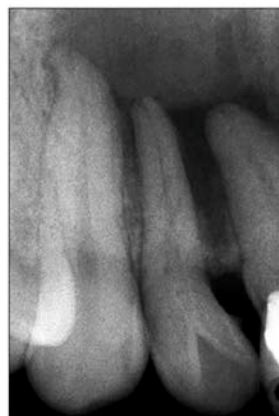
Periapical radiograph of tooth #7 with dens invaginatus Type I.
